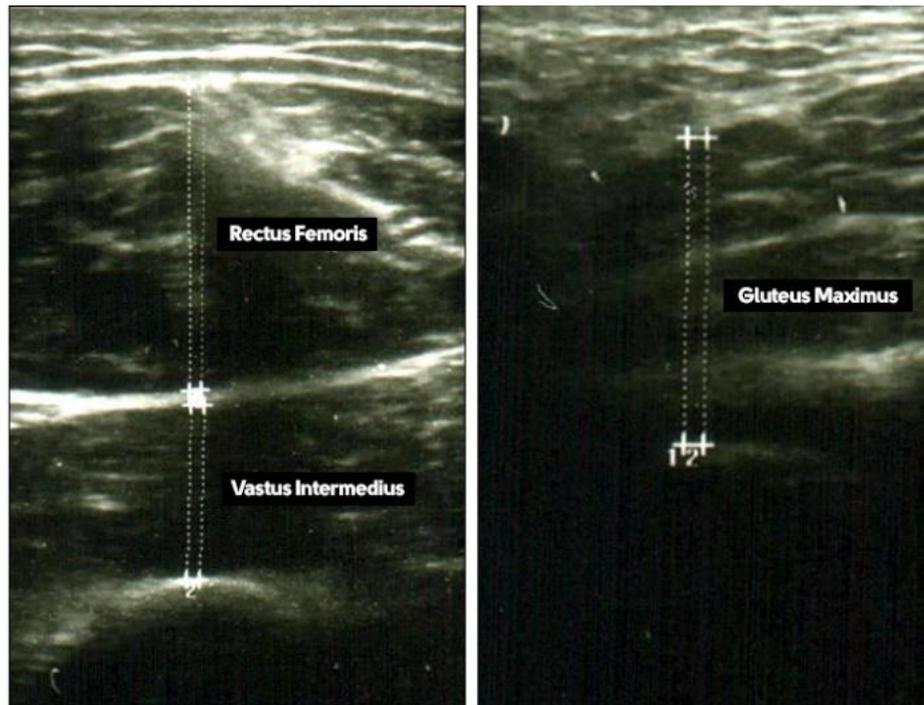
Ultrasound measurements of the rectus femoris, vastus intermedius and gluteus maximus muscles.
